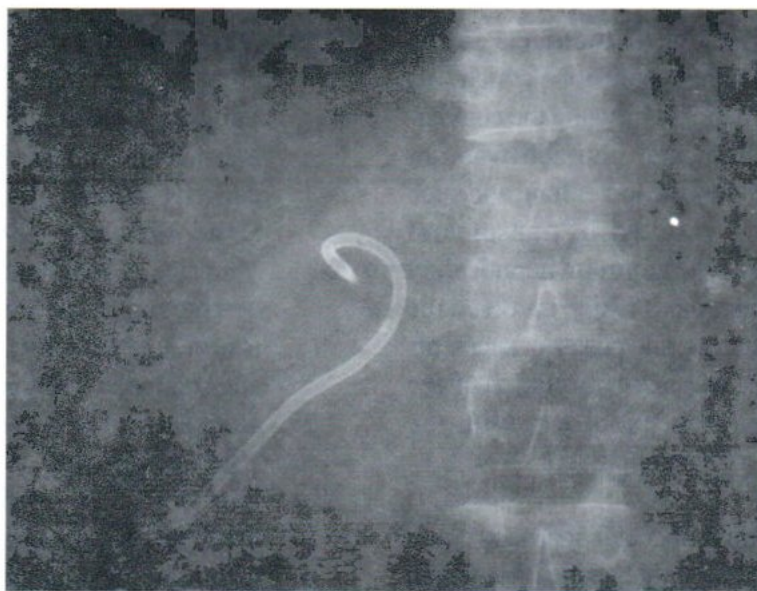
A plain radiograph shows that the tip of the catheter could also be placed in the dilated duct of the anterior segment of the right hepatic lobe proximal to the stricture to provide simultaneous decompression of these 2 segments with a single catheter.
